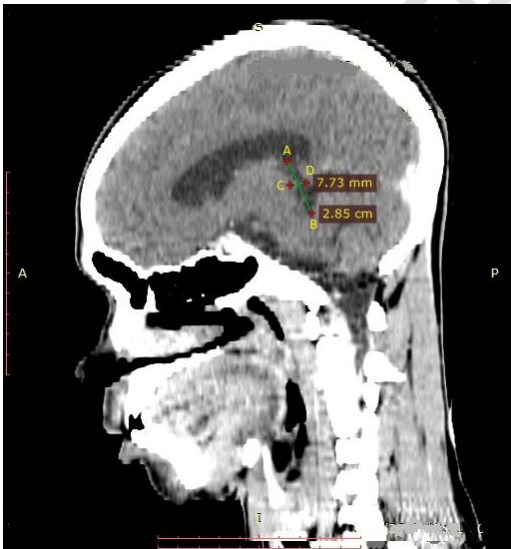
A CT image showing measurement of the anterior-posterior diameter (A-B) and transverse diameter (C-D) of cerebral aqueduct.
